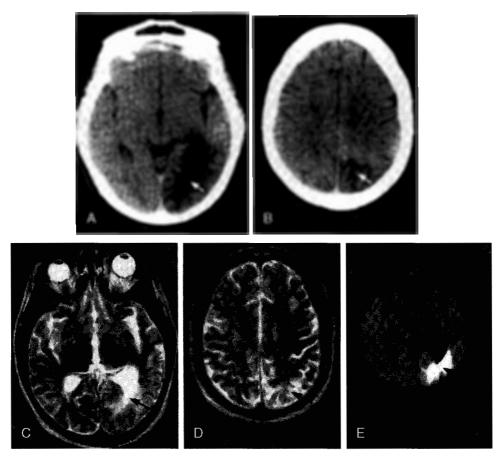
CT scan demonstrating an ischemic stroke (*arrows*) in the left posterior temporal, occipital, and parietal region in a young female patient who was later diagnosed with moyamoya disease (*A* and *B*). *C*, MR image with exacerbation of symptoms during preoperative evaluation that now demonstrates both the old stroke (*C* and *D*) and a new area of infarction demonstrated on the diffusion MR image (*E*).
